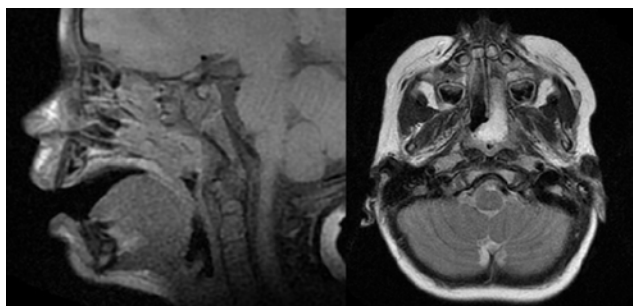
Magnetic Resonance Imaging of the patient was shown.
